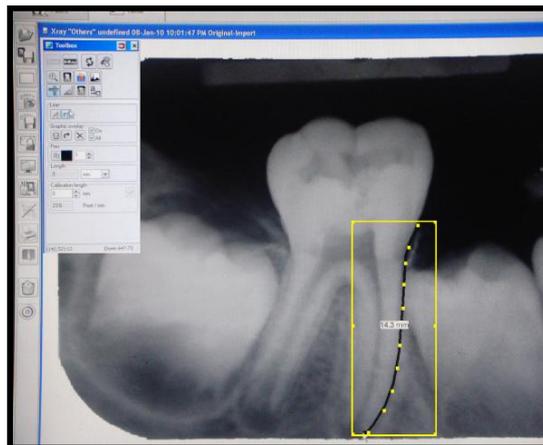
Linear radiographic measurement for root development assessment of a mandibular 1st permanent molar with incompletely formed root prior to treatment using vista scan imaging system
